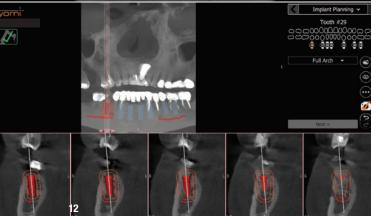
Placement of the pilot drill into the surgical site via dynamic live CBCT navigation. Figs. 4b&c: Osteotomy was completed to the sinus floor with confirmation of depth via dynamic live CBCT navigation. Fig. 5: Placement of the ceramic implant (2.2_5411, SDS) to 35 Ncm. Fig. 6: PRF covering with allograft. Fig. 7: Postoperative radiograph showing accurate implant placement. Fig. 8a: Initial situation on CBCT showing multiple periapical radiolucencies associated with failing root canals of teeth 19, 21, and 27. Fig. 8b: Horizontal root fracture in tooth 29. Fig. 9: Failing double abutted bridge in teeth 21/22-27/28. Figs. 10a & b: Pre-surgical planning using CBCT and Yomi. Fig. 11: Preoperative maxillary, mandibular and bite scans to aid in temp mock-up. Fig. 12: Immediate implantation in site #29 using the Yomi robot with haptic controls and locked drill path depth and angulation.
